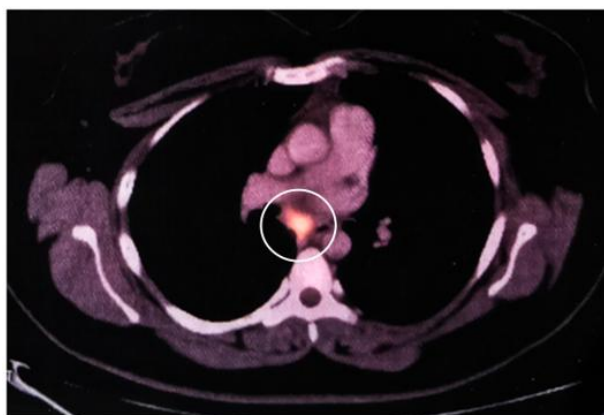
¹⁸F-FDG-PET/CT scan shows minor FDG avid right paratracheal, AP window, and subcarinal lymph nodes (mark by white circles).
